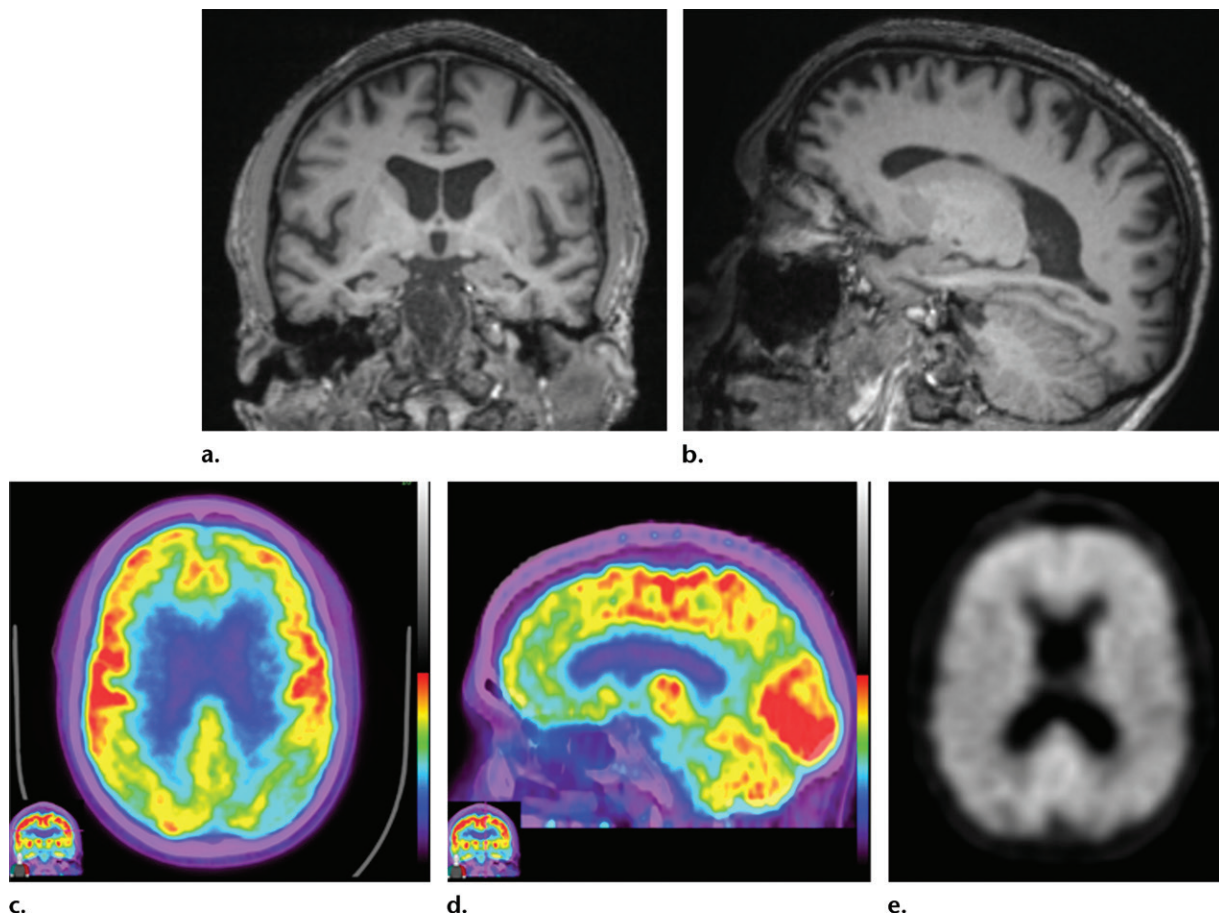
Alzheimer disease. (a, b) Coronal (a) and sagittal (b) T1-weighted MR images in a patient with suspected Alzheimer disease show mild-to-moderate generalized volume loss. (c, d) Axial (c) and sagittal (d) ^{18}F -FDG PET images show markedly decreased activity in the bilateral frontal lobes and precuneus. Image insets show a coronal section through the middle of the brain in this particular case to aid in lateralization. (e) Axial ^{18}F -florbetaben image shows diffuse cortical uptake, which is a grossly abnormal finding, confirming amyloid deposition. Corroborative imaging findings are supportive of the clinical diagnosis of Alzheimer disease.
